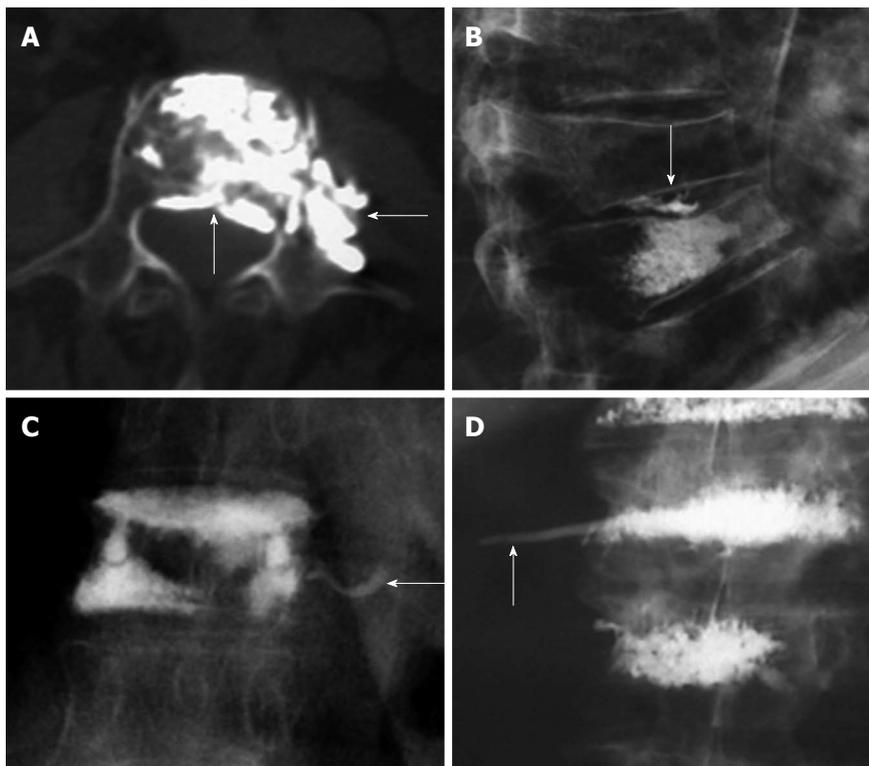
Axial computed tomography shows extravasations to epidural space and paravertebral area (arrows) (A), leakage to the intervertebral disc (arrow) (B), venous leakage (arrow) (C), tail of cement in the path of the needle (arrow) (D).
